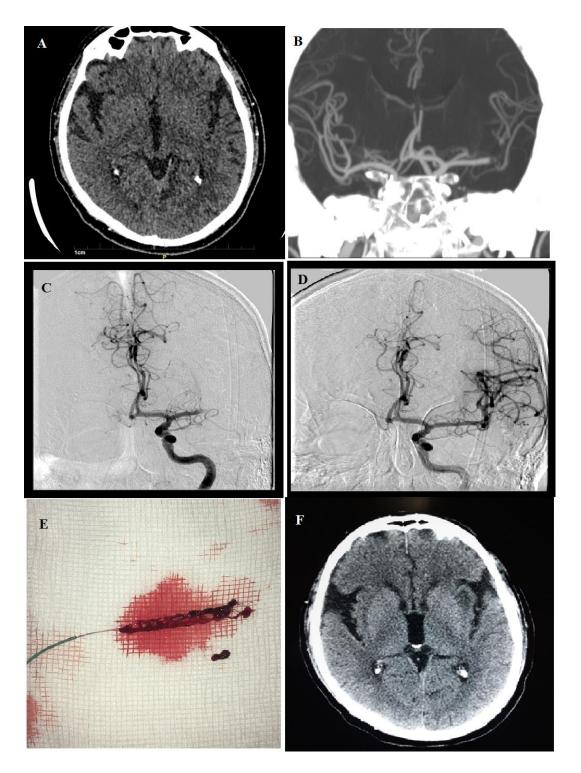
A 79-year-old male with NIHSS 9, ASPECTS 9 (A), and left M1 occlusion on CTA (B). Arterial puncture was initiated 4 hours and recanalization and recanalization achieved 4.35 hours after symptom onset. DSA confirmed existence of left sided M1 occlusion (C). DSA after the recanalization (D). Clot captured within the stent retriever mesh (E). Post 24-hour CT demonstrated small infarction at the level of insula (F). Day one NIHSS was 3, and 90 days mRS was 0.
